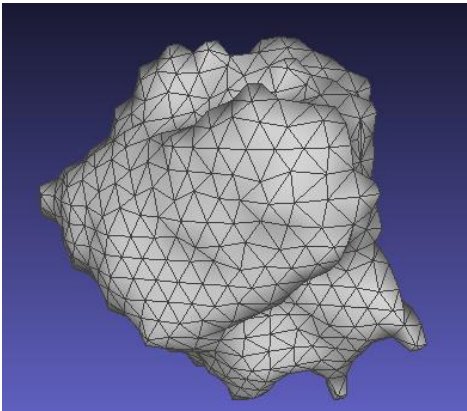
STL of the segmented tumor from MRI 05 using one smoothing step in the Laplacian Smoothing tool in *Meshlab*.
